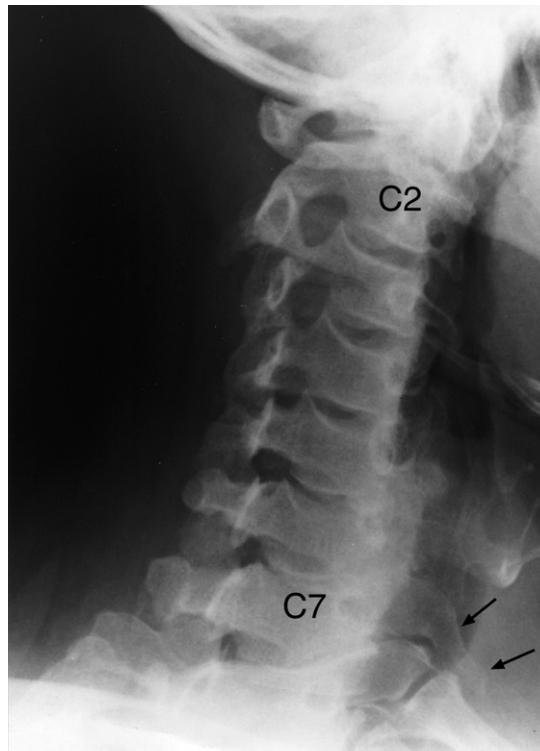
Cervical spine oblique plain X-ray image. Note one of the small bilateral bony C7 cervical ribs (arrows).
